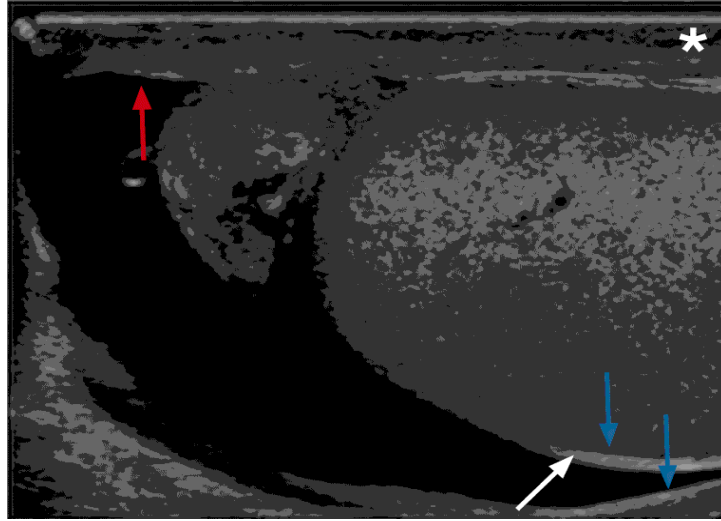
Scrotum. Normal scrotal skin thickness varies between 2-8 mm (radiopaedia2017). Sonogram of the testicle effectively demonstrates the tunica albuginea which envelopes the testicle (red arrow). The testicle with its tunica albuginea is covered by the visceral layer of the tunica vaginalis (white arrow). The inner aspect of the scrotal wall (asterisk) is covered by the parietal layer of the tunica vaginalis (blue arrows). Normally both layers of the tunica vaginalis are only separated by a small amount of fluid; however, in this case there is a moderate amount of fluid separating the two layers that allows a good demonstration of the anatomy (ultrasonography.org).
